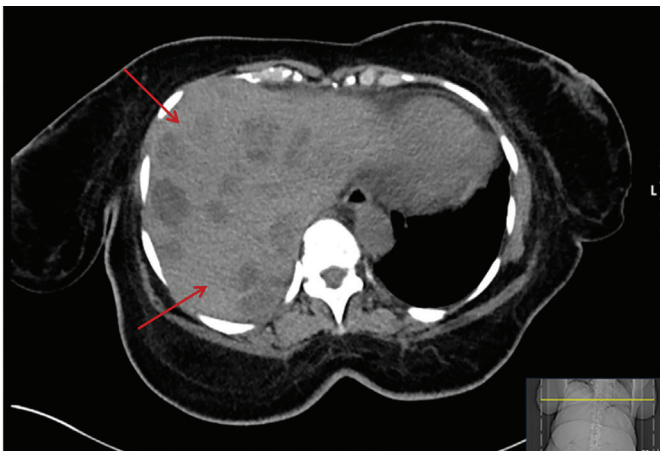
Axial computed tomography of the abdomen and pelvis demonstrating multiple complex, septated cystic lesions in the liver, consistent with multiple abscesses.
